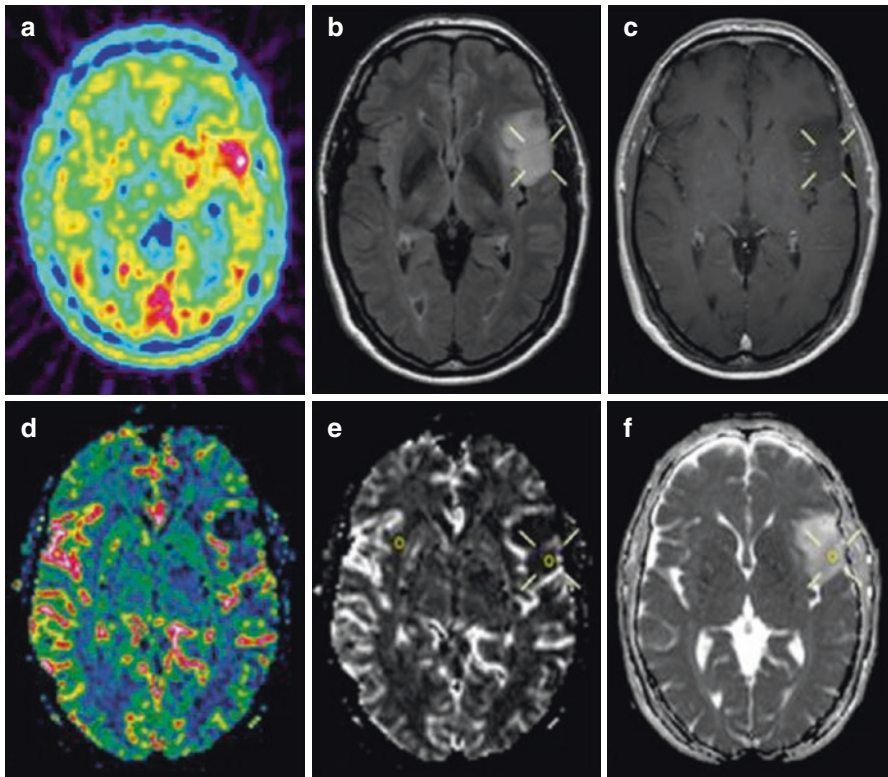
Preoperative ^{11}C -methionine-PET and MRI of a patient with a left-sided frontal astrocytoma grade II. (a) PET study shows the hot spot area in the tumor (hot spot/cortex ratio 1.6). (b) T2-weighted FLAIR MRI shows a high signal intensity tumor. (c) T1-weighted contrast-enhanced MRI shows a non-enhancing hypointense tumor. (d) Perfusion-MRI with rCBV color map shows low perfusion in the tumor area. (e) Perfusion-MRI with rCBV grey-scale map shows low perfusion in the region corresponding to hot spot on PET. The region of interests in the tumor and the contralateral normal appearing white matter are shown. (f) Diffusion-MRI shows increased mean diffusion in the region corresponding to the hot spot on PET
